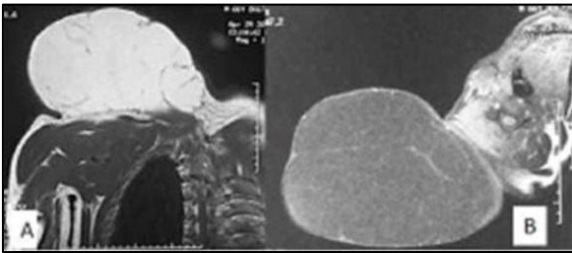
MRI of scapular region showing the mass with muscles contact, regular aspect, without locoregional invasion
